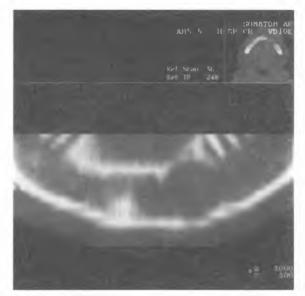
CT multiplanar reconstruction along an irregular line imitating panoramic X-ray demonstrates intact cortical bone around an expansile lesion of mandibular body
